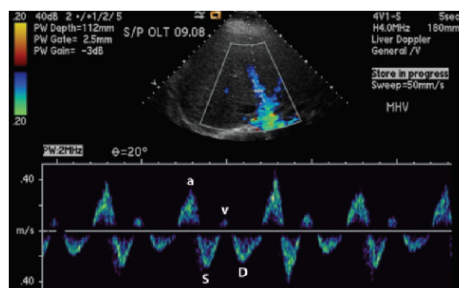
Right-sided CHF without tricuspid regurgitation. Spectral Doppler image clearly shows increased pulsatility. Careful observation shows a pattern that is specific to right-sided CHF without tricuspid regurgitation. The *a* wave is very tall, and the normal relationship between the *S* and *D* waves is maintained (*S* [systole] is deeper than *D* [diastole]).
